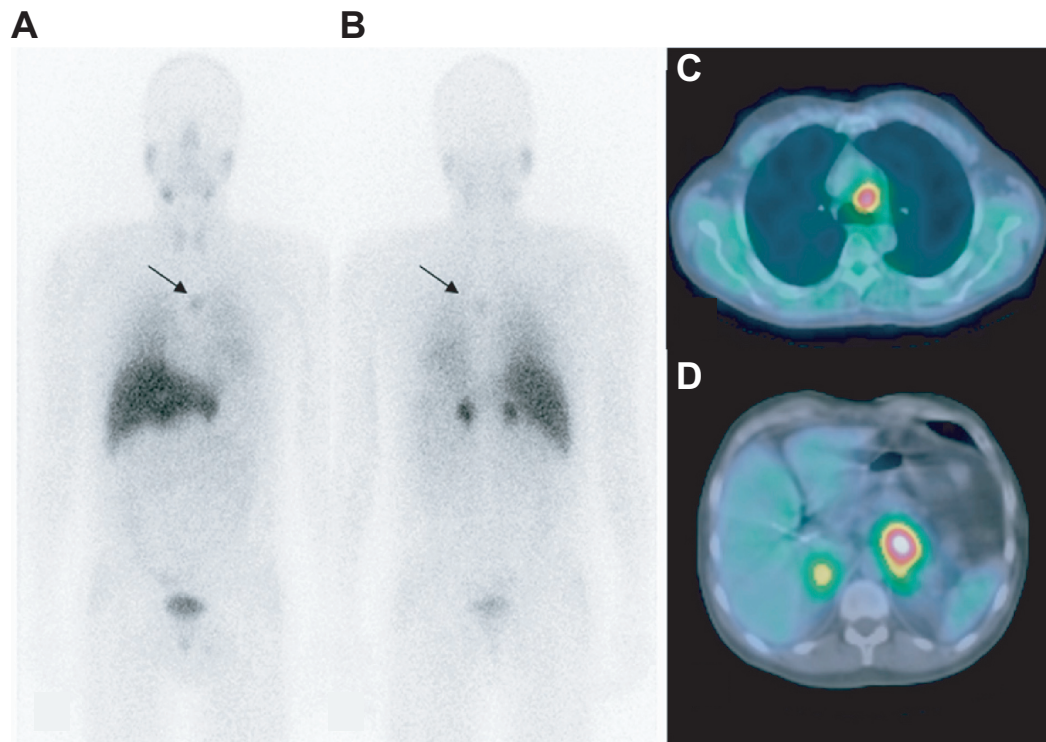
^{123}I -MIBG scintigraphy performed in a hypertensive patient with bilateral adrenal pheochromocytomas. Anterior (A) and posterior (B) whole-body scintigraphy and fused SPECT/CT image (D) obtained with a hybrid machine clearly depict and correctly localize both pheochromocytomas. An unsuspected additional focus of uptake is seen in the thorax (arrow), and it is localized in the aortopulmonary window, as demonstrated by SPECT/CT images (C). Copyright © 2006. Reprinted by permission of Elsevier Inc. from Rufini V, Calcagni ML, Baum RP. Imaging of neuroendocrine tumors. *Semin Nucl Med.* 2006; 36(3):228–247.
